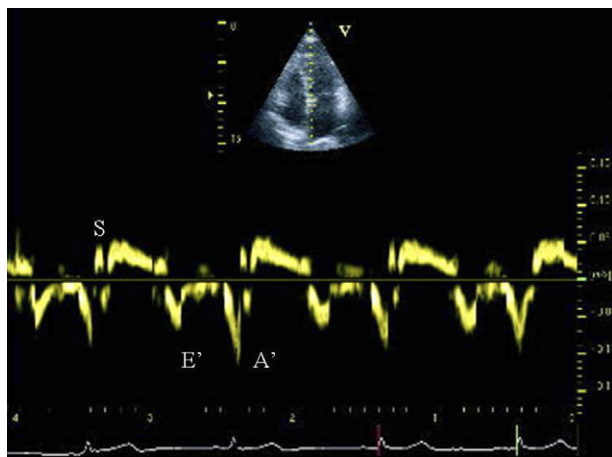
Pulsed wave Doppler tissue imaging with sample volume placed on the atrial side of the septum. S, systolic velocity; E', early diastolic left ventricular relaxation; A', atrial contraction in late diastole.
